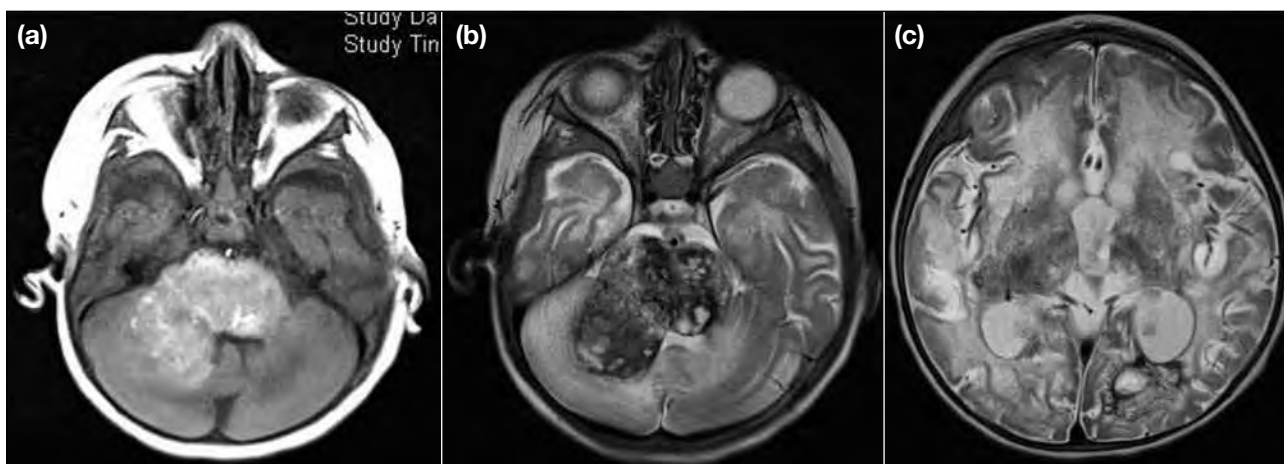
Magnetic resonance imaging scans showing (a) infiltrative intense T1 signal involving the cerebellum, and (b, c) high-intensity T2 signal and blooming in bilateral cerebrum and cerebellum in patient 1.
